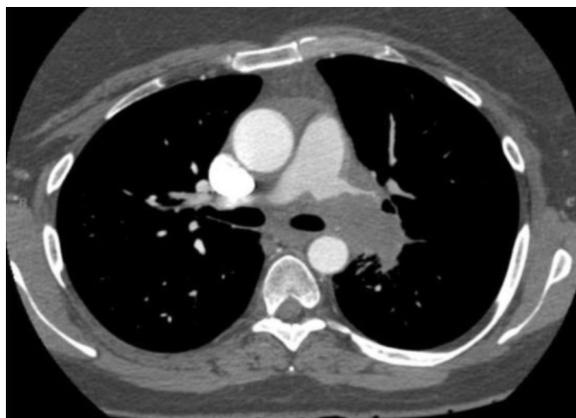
41-year-old woman with chronic pulmonary embolism. Axial CT image of the chest demonstrating a mass extending outside the vessel wall with a large filling defect involving the left main pulmonary artery and extending into all sub-branches.
